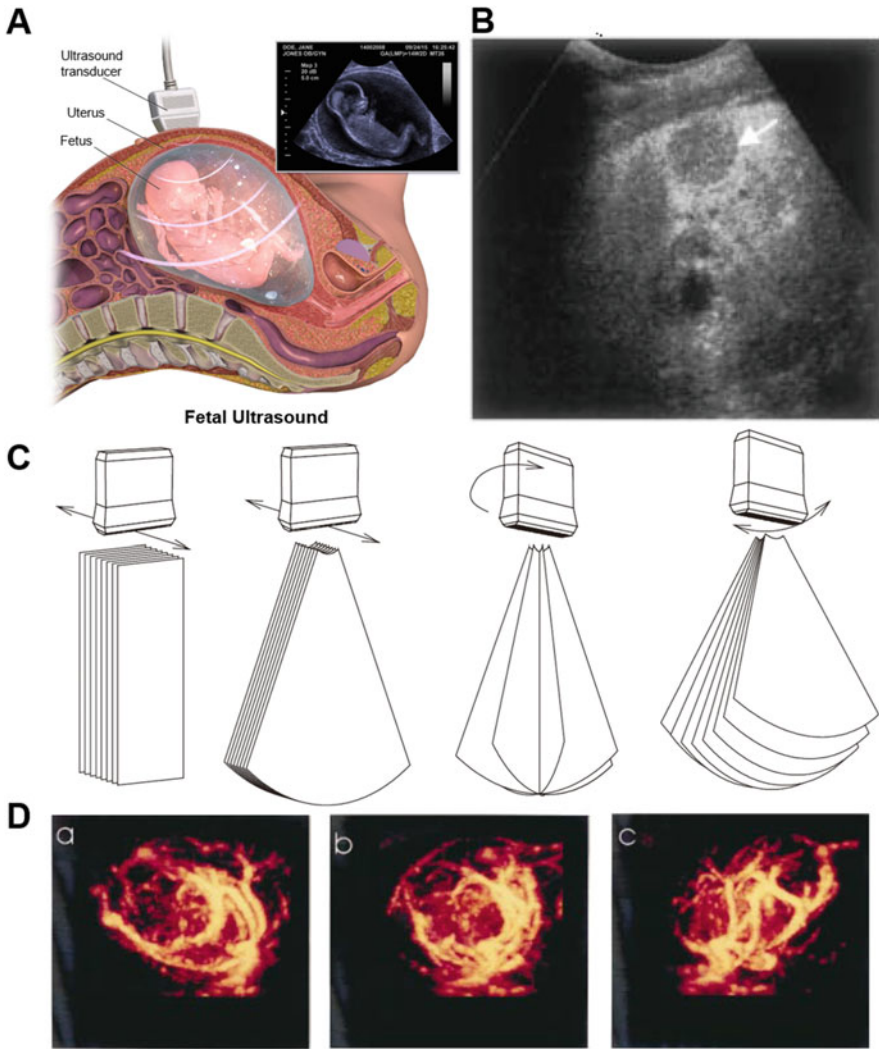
Medical applications and advances of ultrasound imaging in oncology. (a) A scheme of the most popular application for medical ultrasound – fetal ultrasound. (b) Ultrasound image of the microvascular hemodynamics of a liver metastasis (arrow) using the method of interval delay imaging. (c) Different methods for mechanical 3D ultrasound scanning. (d) Example of three-dimensional reconstructions of a VX2 tumor growing in a rabbit thigh
